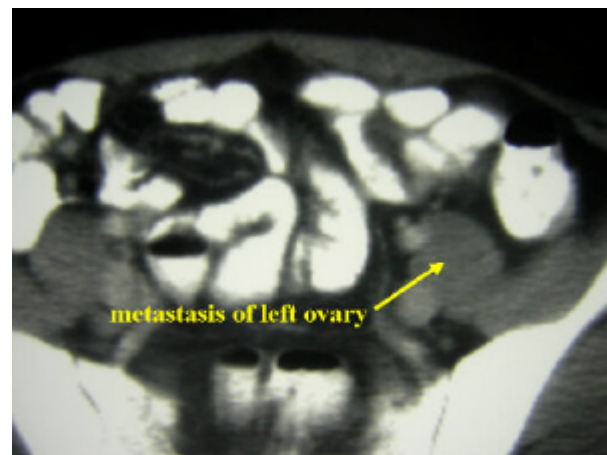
Abdominal CT scan of the metastasis in the left ovary.
